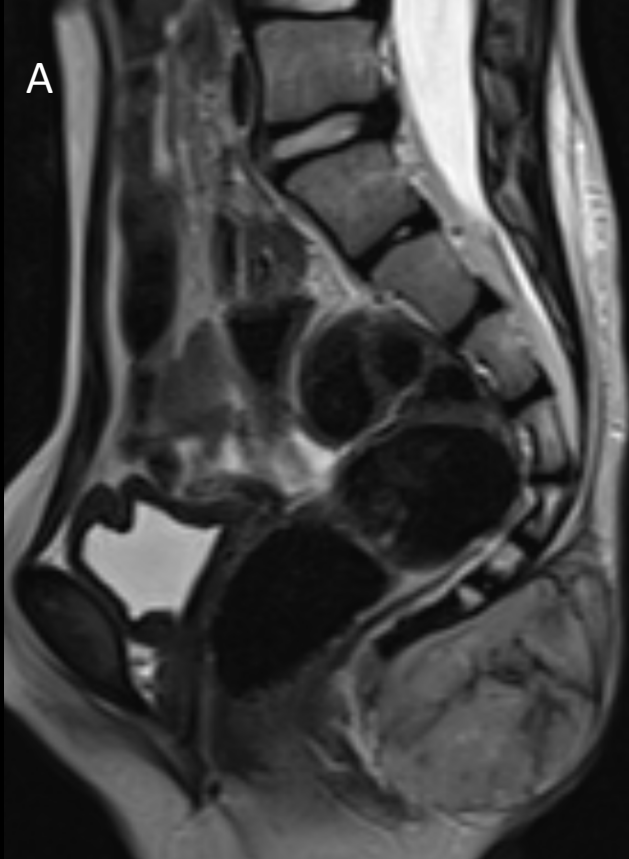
T2W images in sagittal (A), coronal (B) and axial (C) planes demonstrating well demarcated mass superficial to and abutting the coccyx and distal sacrum, with heterogeneous signal and mostly hypointense capsule and some hypointense septa. Mass shows predominant high signal in T2W fat saturated sequence (D). DWI sequence demonstrating heterogeneous mild diffusion restriction (E).
